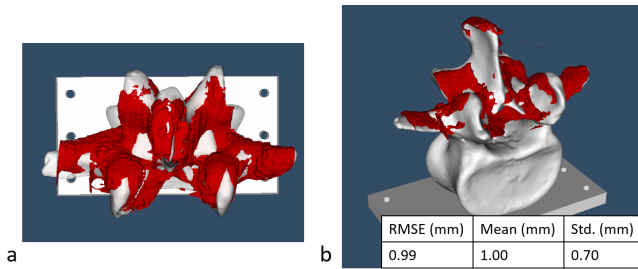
Automatic 3D reconstruction result (red) compared to the spine model obtained from CT scan (white) after ICP. (a) top view of reconstruction result; (b) left side view of the reconstruction result.
